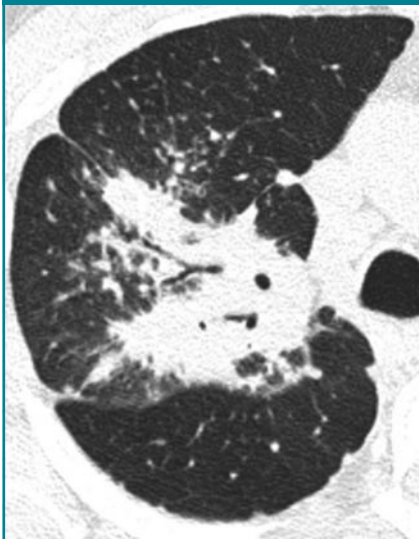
Transverse CT scan shows consolidation with bronchocentric distribution.
